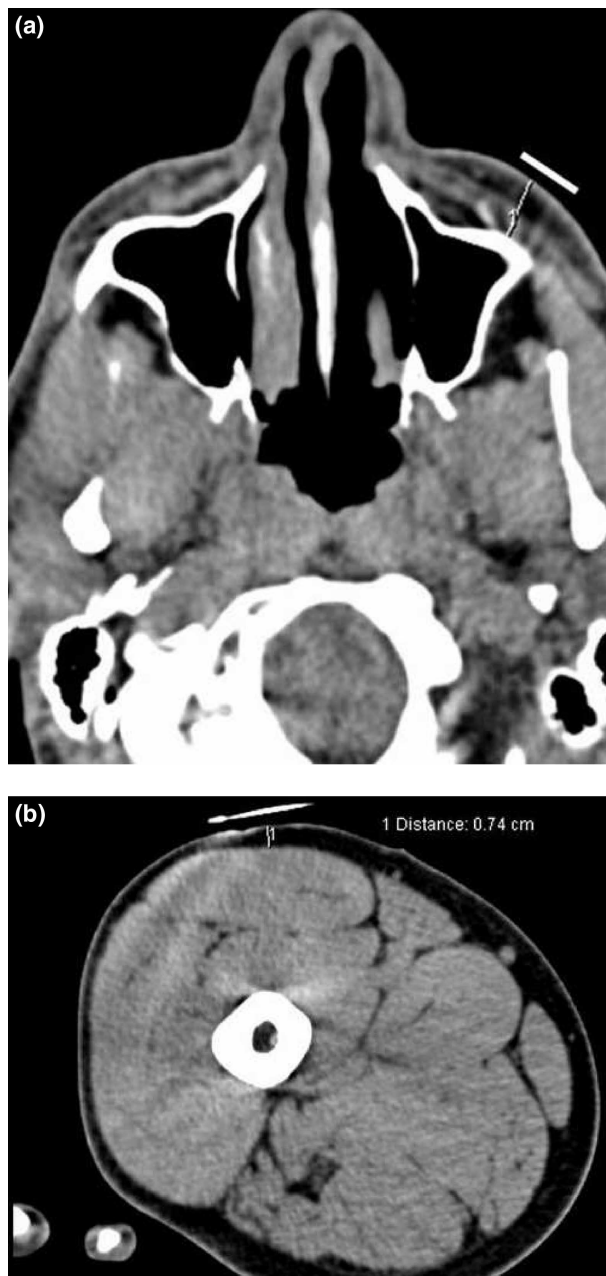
Tomographic measurements of marked facial (A) and lower limb (B) SFT at reference points corresponding to skin areas where sonographic assessments were performed.
